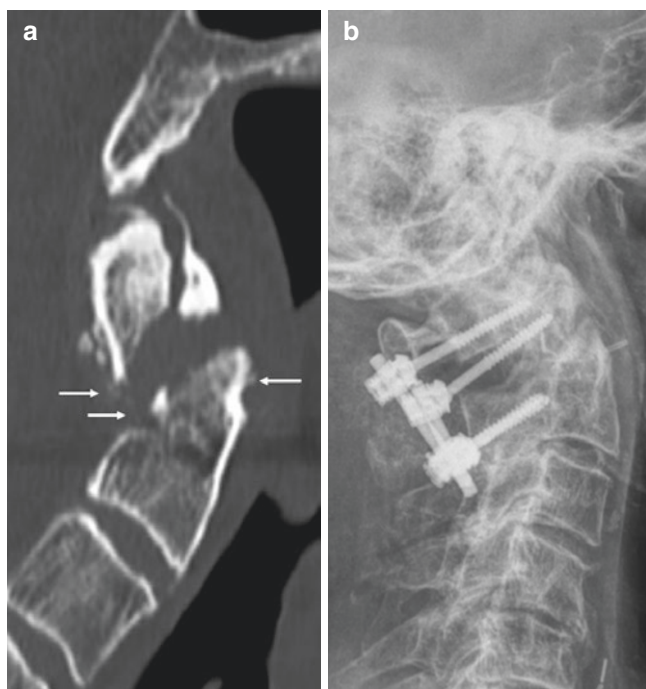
An 85-year-old man with neck pain after unwitnessed fall. (a) Sagittal CT image demonstrates a displaced fracture through the base of the odontoid process, with more than 6 mm of displacement and small chip fragments anteriorly and posteriorly (arrows), consistent with a type IIA fracture. This fracture is unstable and requires surgical management. (b) Subsequent lateral radiograph demonstrates posterior C1–C2 spinal fusion
